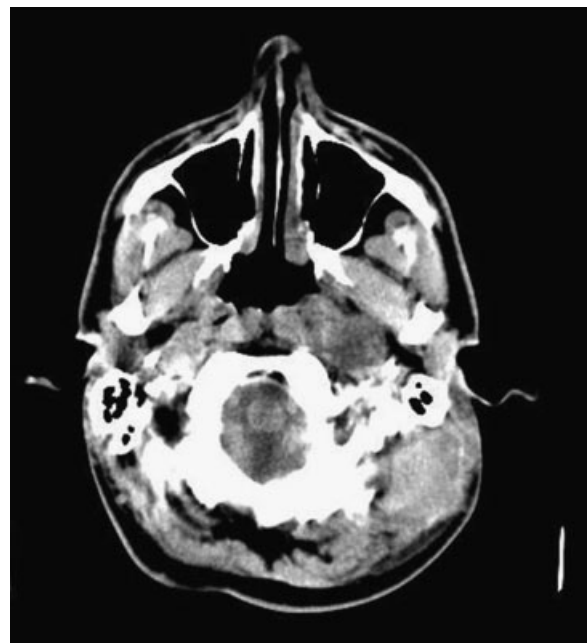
A CT scanner four weeks after surgery showing a soft tissue hematoma on the left retroauricular region as the patient develops a sudden painful lump with important tension.
